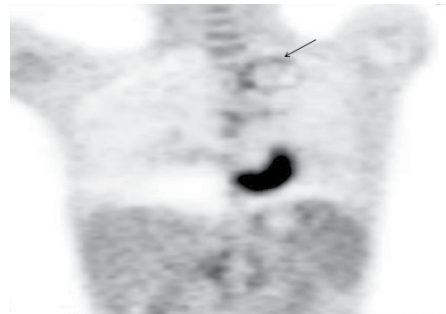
Fluorodeoxyglucose (FDG) positron emission tomography images show FDG uptake (SUVmax: 1.5) at the thickened wall of the dilated left subclavian artery
